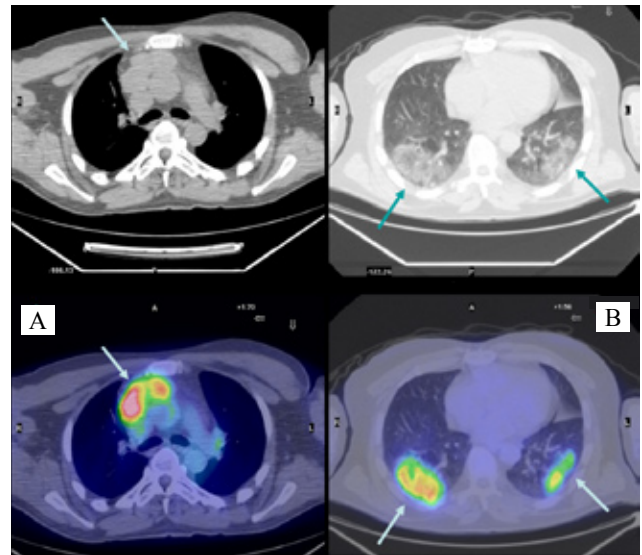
A. Preoperative ^{18}F -FDG-PET/CT. High uptake in the anterior mediastinal tumor. B. ^{18}F -FDG-PET/CT. High uptake in bilateral ground glass opacities of the two lower lobes.
